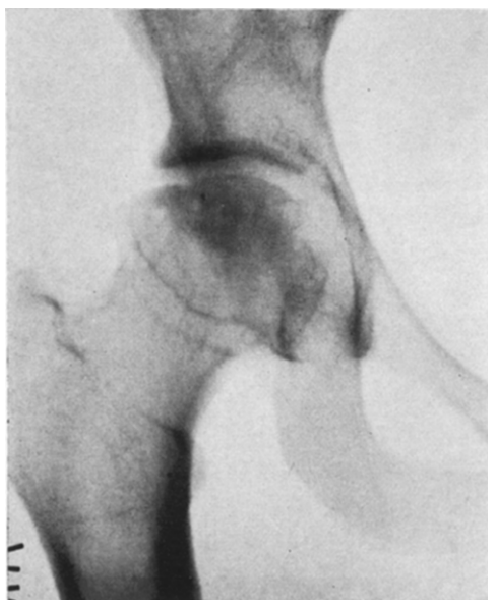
Case 1. Roentgenogram five years later, March 8, 1937; fairly well preserved contour of the head; spur formation with smooth outline on upper border of the neck and head.
